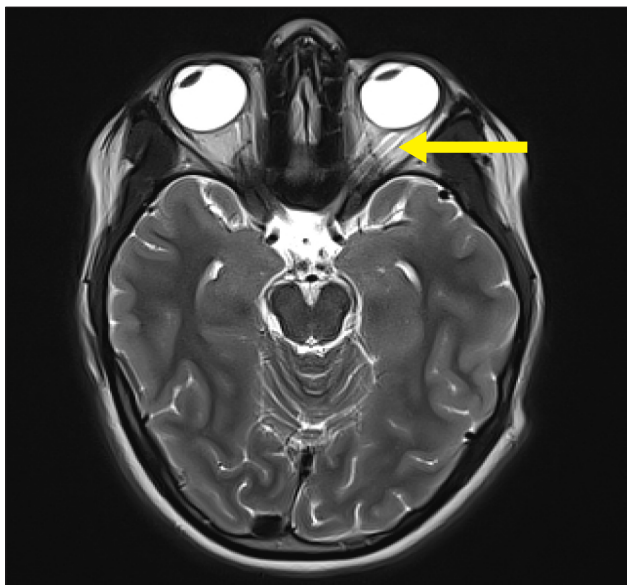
Sagittal magnetic resonance imaging brain and orbits scan showing enhancement of the left optic nerve up to the optic chiasm.
